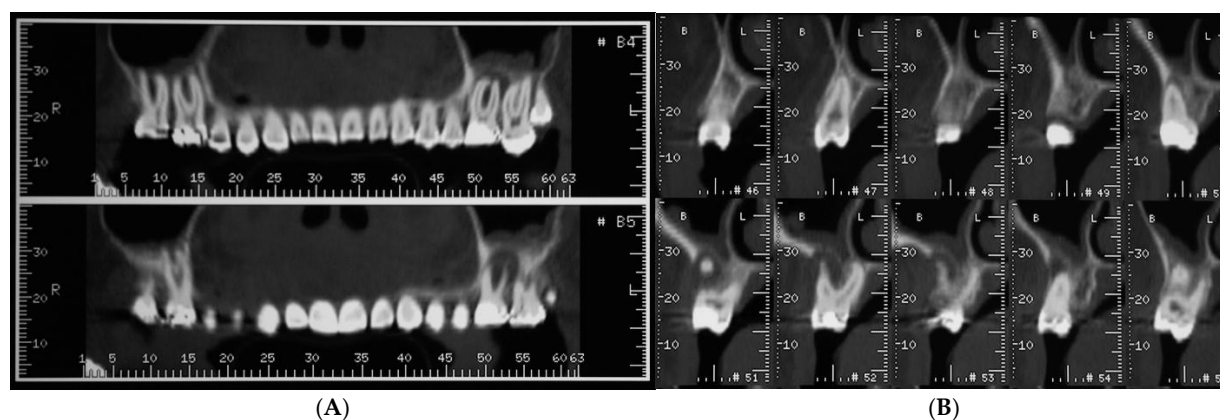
Computed tomography (CT) scans revealed large osteolytic lesion of first maxillary left molar caused by failure of repeated endodontic therapies (A). Cross-sections showing buccal bone loss (B).
